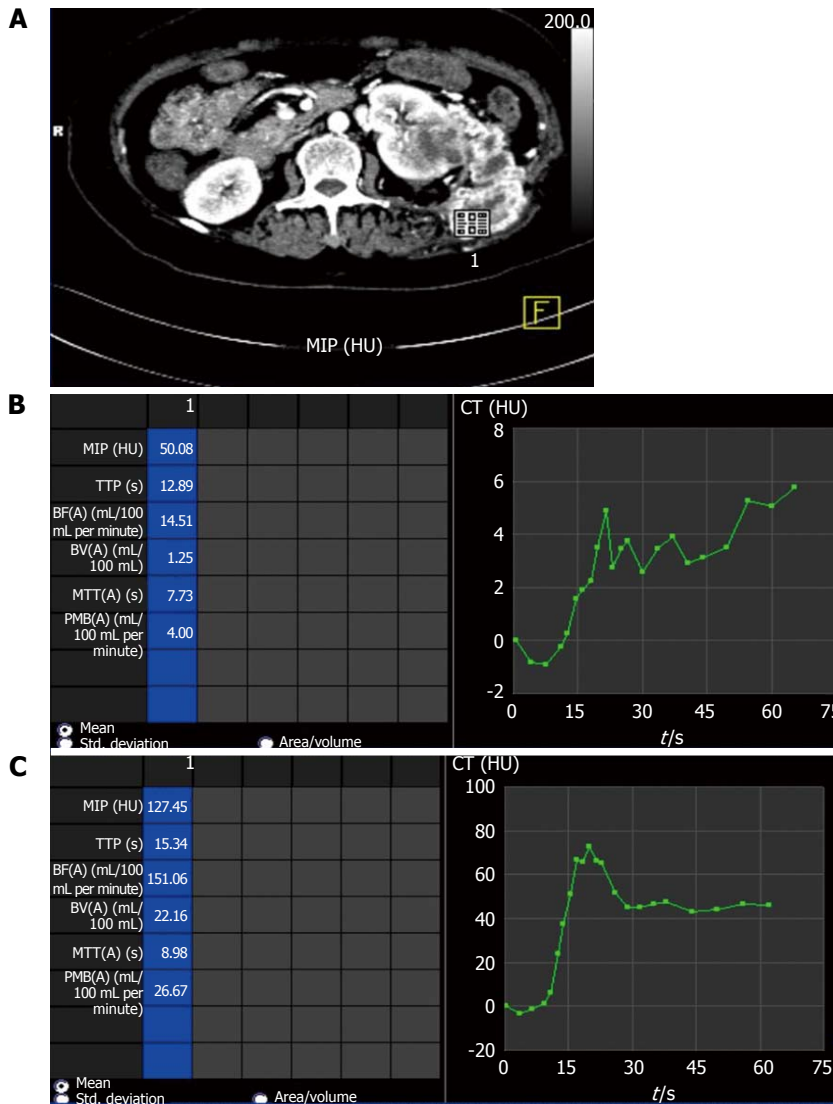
Perfusion parameters showing progressive disease with anti-angiogenic therapy. Comparison of perfusion parameters in left metastatic renal cell carcinoma (A) after start of anti-angiogenic therapy at 6 mo interval shows progressive disease as permeability (PMB) at baseline scan (B) was 4.00 mL/10 mL per minute which increased to 26.67 mL/100 mL per minute in follow-up scan (C). There was also increase in size and extent of lesions during this interval (not shown). MIP: Maximum peak intensity; TTP: Time to peak; BF: Blood flow; BV: Blood volume; MTT: Mean transit time; CT: Computed tomography.
